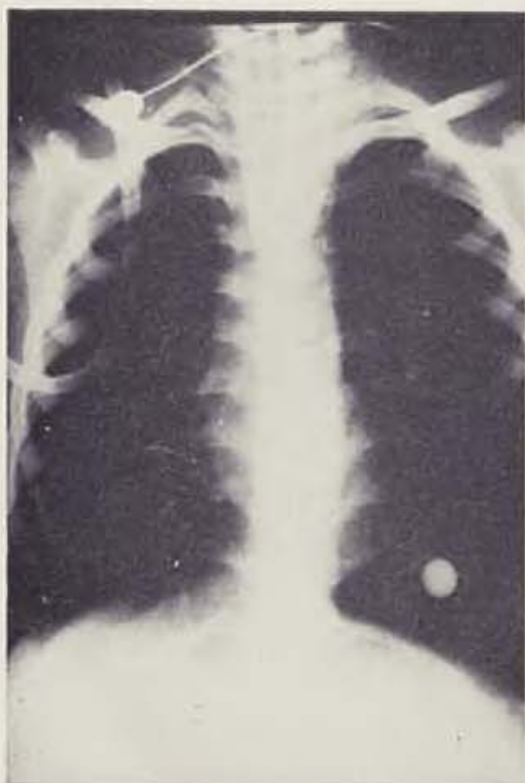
X-ray of the heart and lungs — post-injury day 1. — Fig. 6. X-ray of the heart and lungs — post-injury day 29
